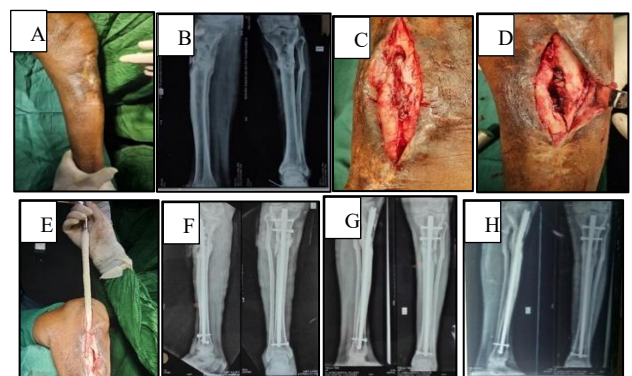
(A-H): Case of 58 Years old male patient with 11 months old infected nonunion of left proximal 1/3rd tibia, Clinical image with discharging wound; Pre op X-ray; debridement of the medullary canal and infected site, post debridement; Intra-op insertion of antibiotic coated nail; Immediate post op X-ray; 3 months post op X-ray; 6 months post op X-ray.
